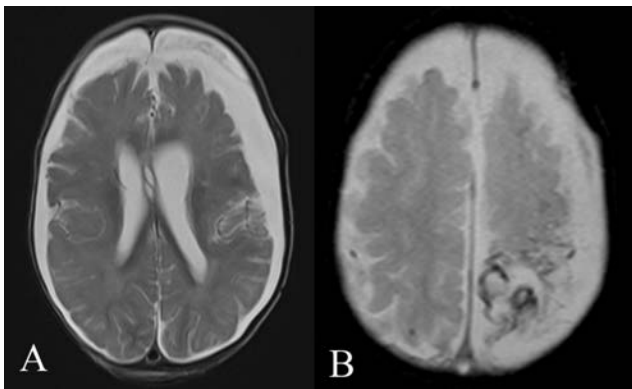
Axial Brain MRI T2W image shows (A) frontal epidural and subdural empyema. (B) Cortical infarction of the left frontal parietal gyrus with hemosiderin deposits.
